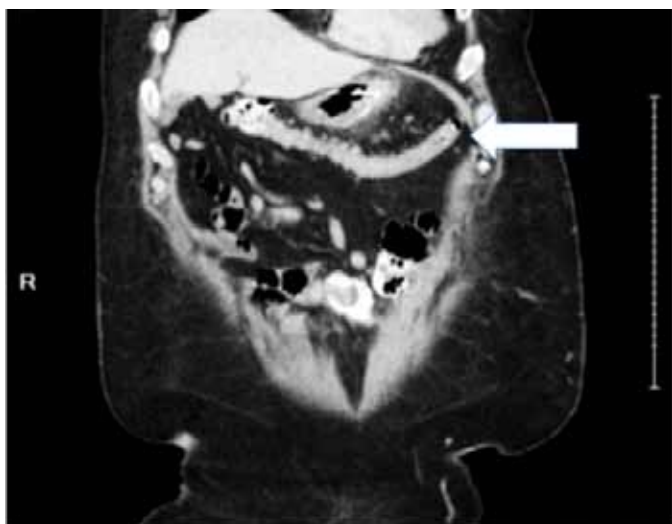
Computed tomography scan demonstrating migration of stent to the jejunum.
